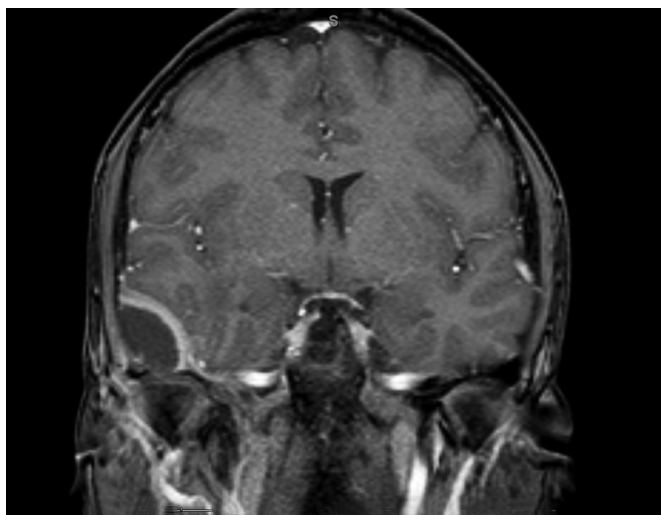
Epidural abscess MRI. Contrast enhanced T1-weighted MRI in coronal section reveals a right-sided low signal collection with surrounding enhancement and medial concave displacement of the dura and brain. T2-weighted images show a similar appearance with high T2 signal of the fluid collection.
